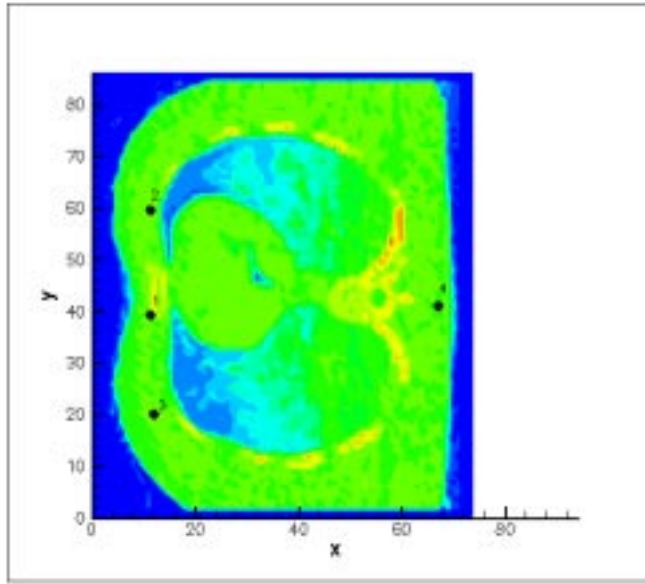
CT image with the four sample points
